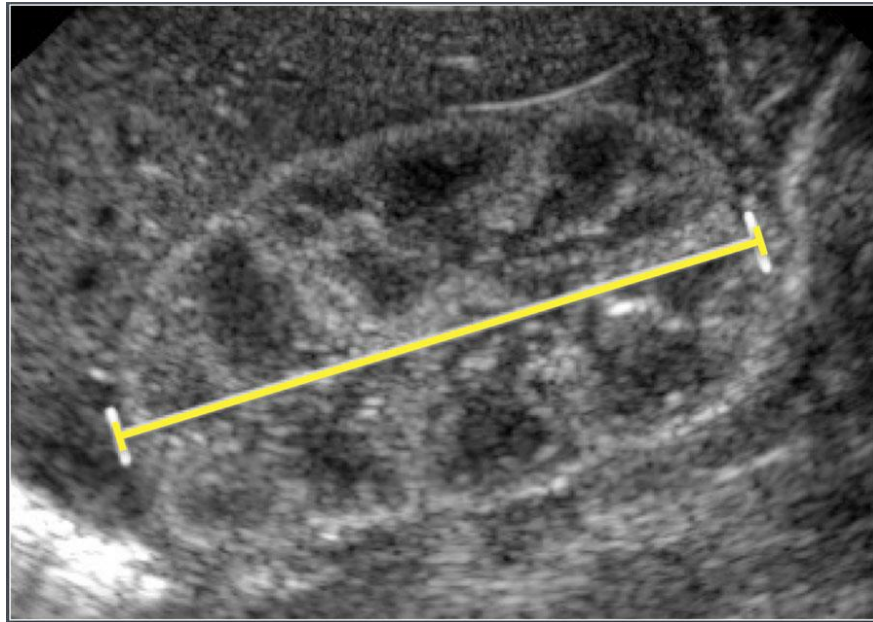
kidney ultrasound longitudinal measurement
